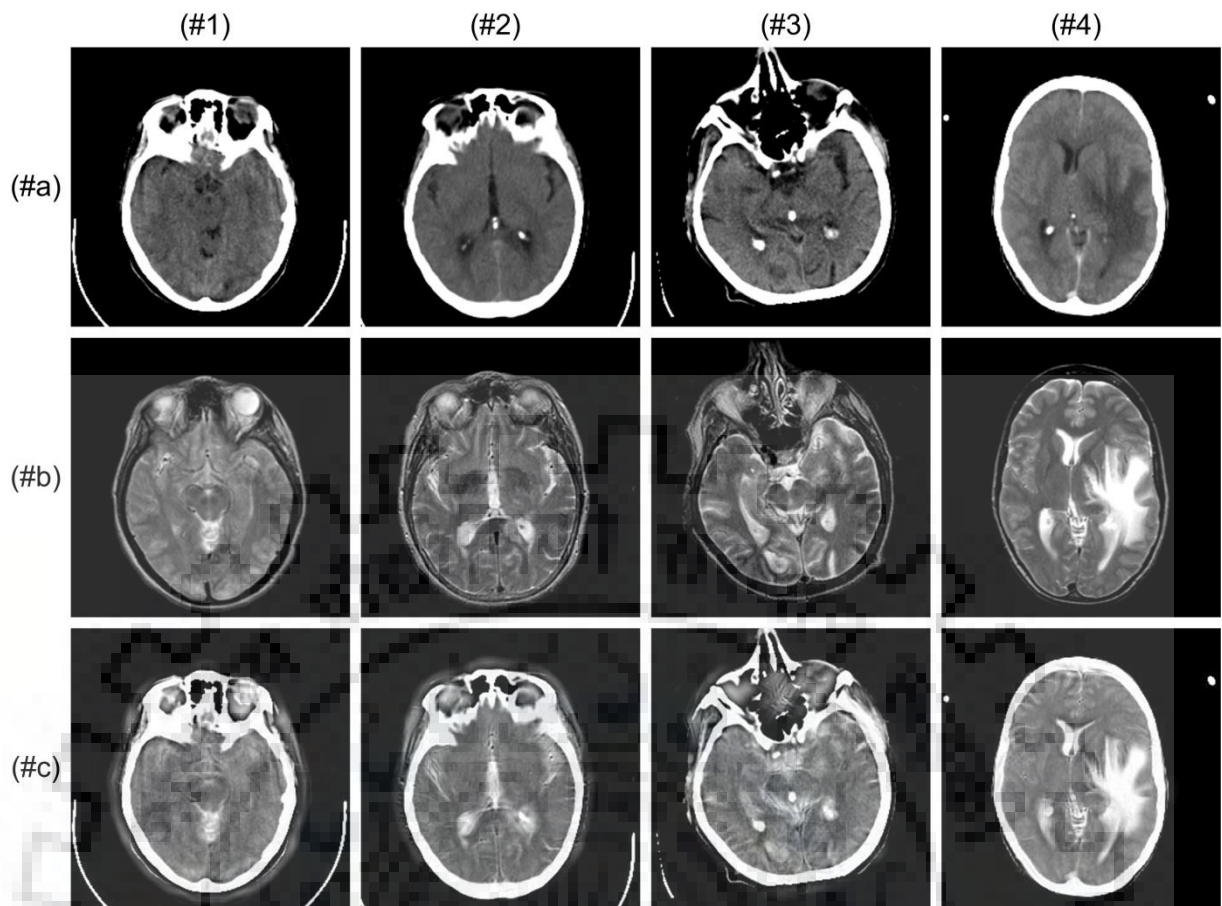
Source (a) CT images, (b) MR images (c) visual performance of fused images evaluated by the proposed C-MIF approach
